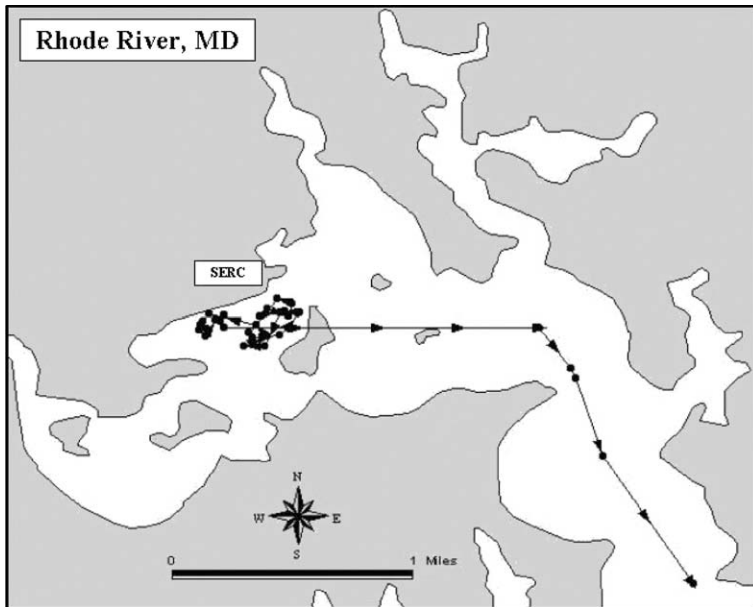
Movements of a female crab tracked by ultrasonic pinger. The pattern of alternating meandering and directed movements is typical of females tracked in the Rhode River and adjacent bay in this study and of males in previous studies. This individual was released 7 June 1999 near the Smithsonian Environmental Research Center (SERC), tracked for 19 days until it moved out of tracking range and was never recovered. Circles: position fixes (generally twice/day). Arrows: most direct vector of movement.
